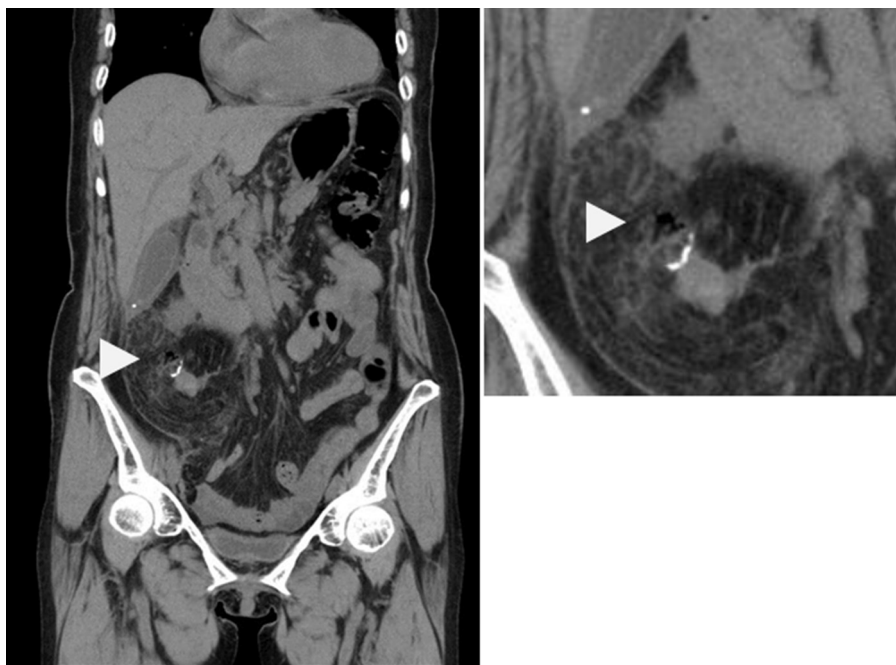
Computed tomography. Computed tomography shows free air (arrowhead) beside the anastomotic site with the elevated density of fat tissue.
